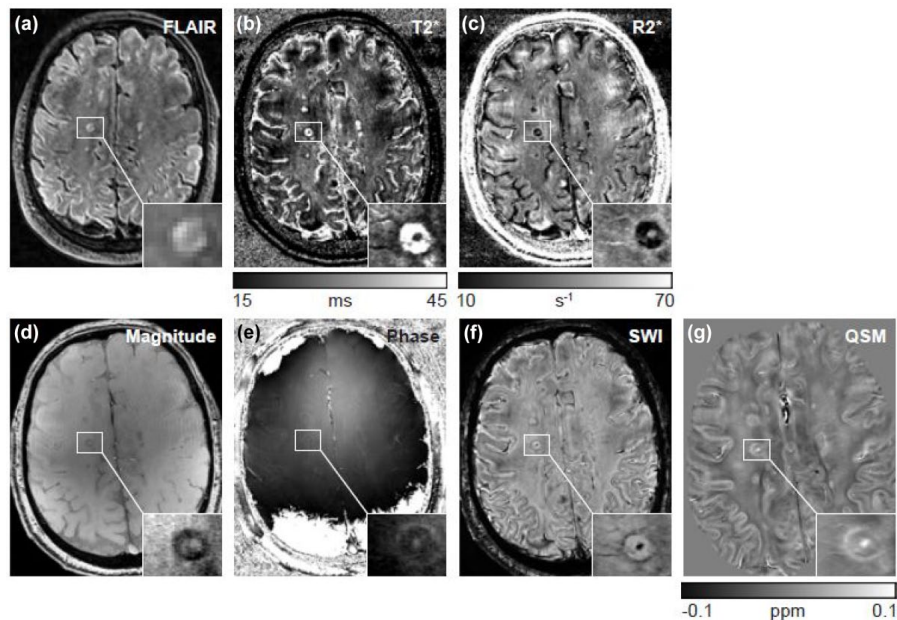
Example of a PRL captured with various MRI sequences. MRI scans were acquired at 7 T MRI from a 33-year-old person with RRMS for 10 years and an MS Severity Score of 0.13. The PRL is located in the supratentorial white matter of the right hemisphere and magnified in the lower right corner of each panel. Panel (a) shows the hyperintense FLAIR lesion, which presents a paramagnetic rim on T2* (b) as a hypointense signal; on R2* (c) as a hyperintense signal; on magnitude (d) as a hypointense signal; on phase (e) as a hyperintense signal; on SWI (f) as a hypointense signal; and on QSM (g) as a hyperintense signal. In addition to the rim, the lesion shows an intralésional punctate feature indicative of a central vein, as well as horizontal veins in the perilesional region. Each sequence provides unique contrast characteristics that contribute to the delineation of PRLs in MS.
